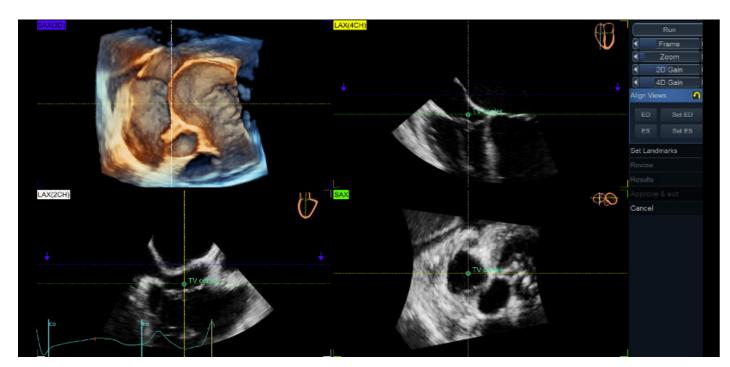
TV quad view showing the alignment of the views and planes with 4D Auto TVQ on a transesophageal TV data set
